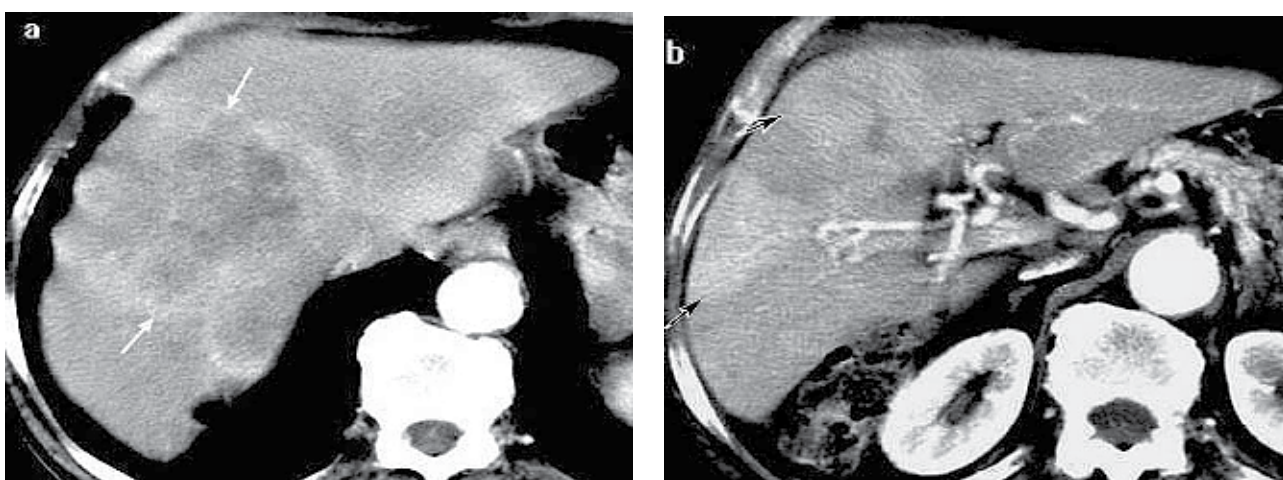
Arterio-portal shunt and hepatocarcinoma. (a), (b)- arterial helical CT: polycyclic hepatic mass (white arrows) and distal peripheral wedge-shaped hepatic parenchymal enhancement (black arrows).
